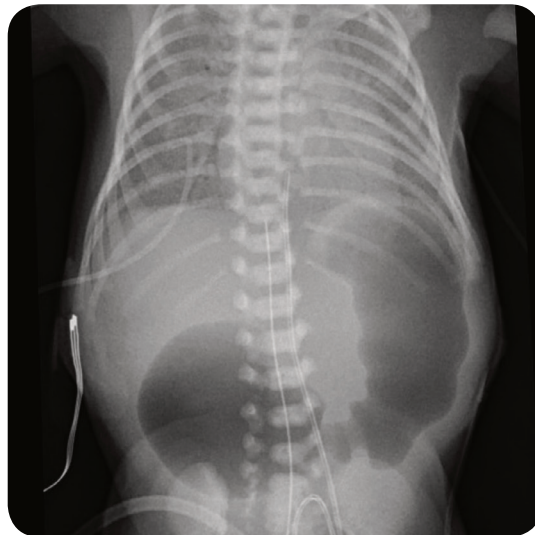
A plain abdominal radiograph of a neonate demonstrating the double bubble sign of duodenal atresia.
